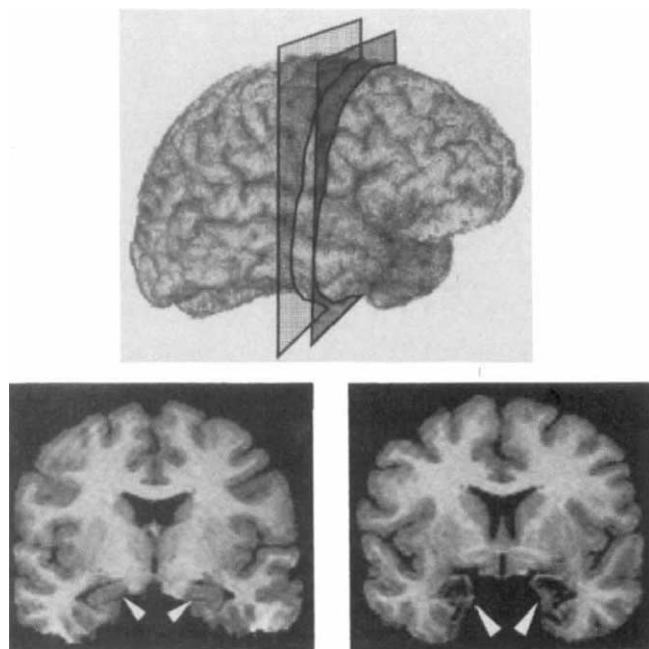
t_1 -weighted MR images of S.M.'s brain. Planes of section are shown at the top, on a three-dimensional reconstruction²⁶ of S.M.'s brain. There is extensive bilateral amygdala damage (lower right image, large arrowheads) with sparing of neocortex and hippocampus (lower left image, small arrowheads). The tissue of the amygdala has been replaced by mineral deposits as a result of Urbach-Wiethe disease¹¹.
